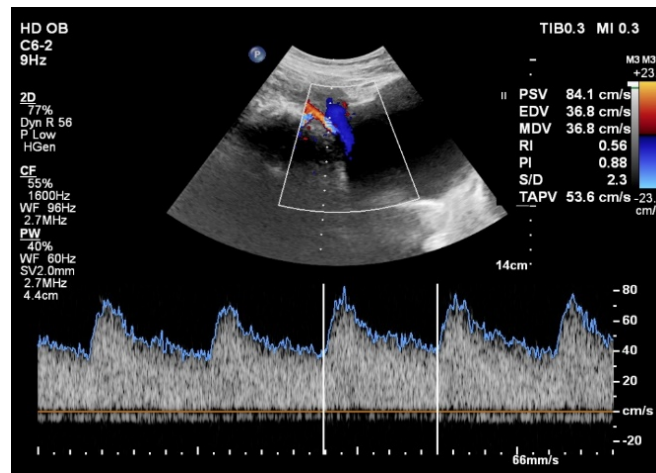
Normal uterine artery doppler
